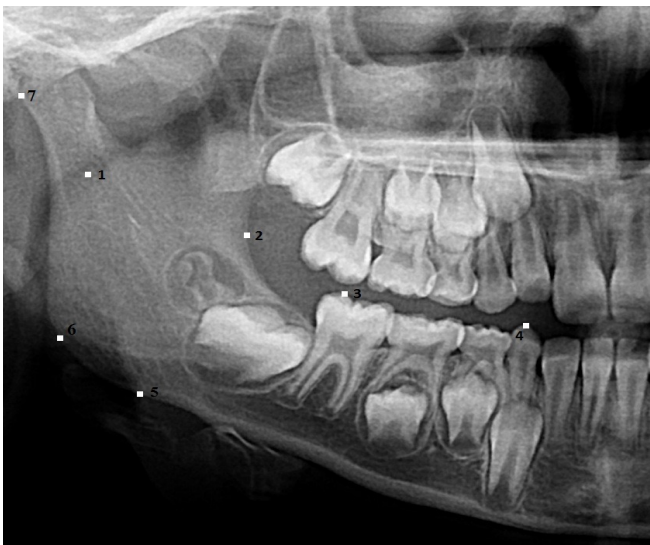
Points of the study drawn on the radiograph.
